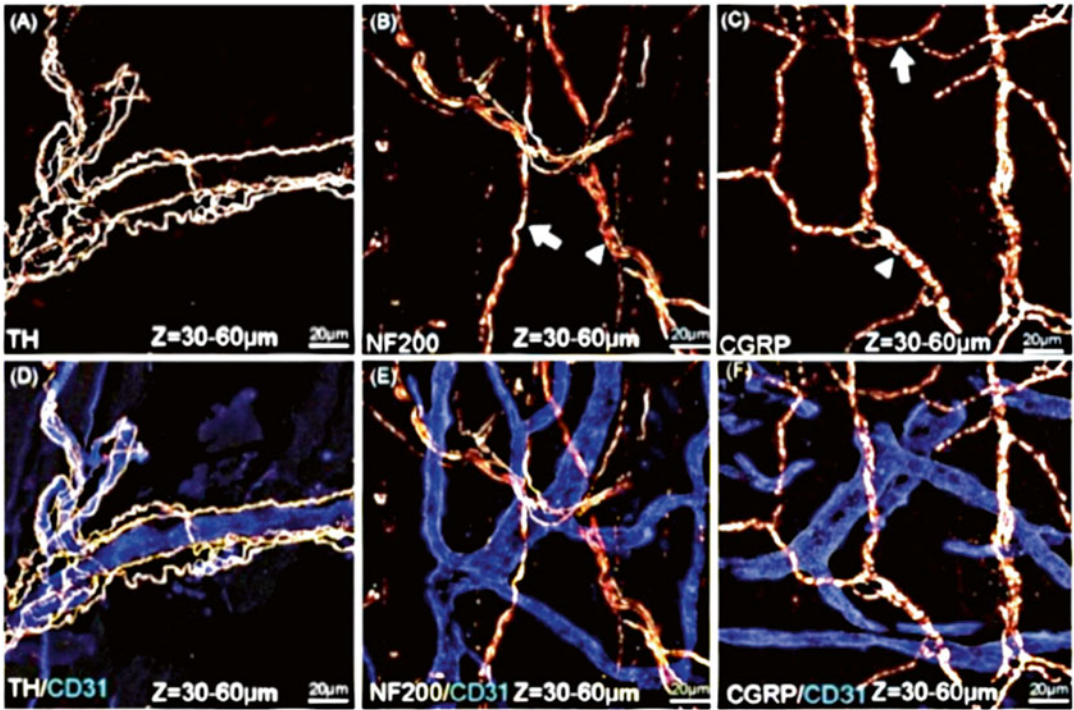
Close association of sensory and sympathetic nerve fibers with blood vessels in the bone periosteum: High-power computed tomography scans of bone in cross section overlaid by confocal images. (a) Sympathetic nerve
